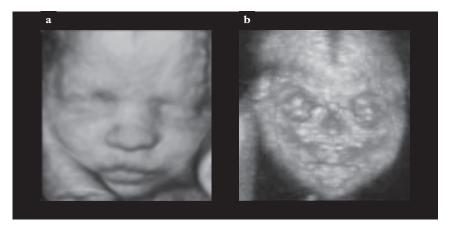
Examples of rendered ultrasound pictures of the face using surface (A) and maximum (B) mode
